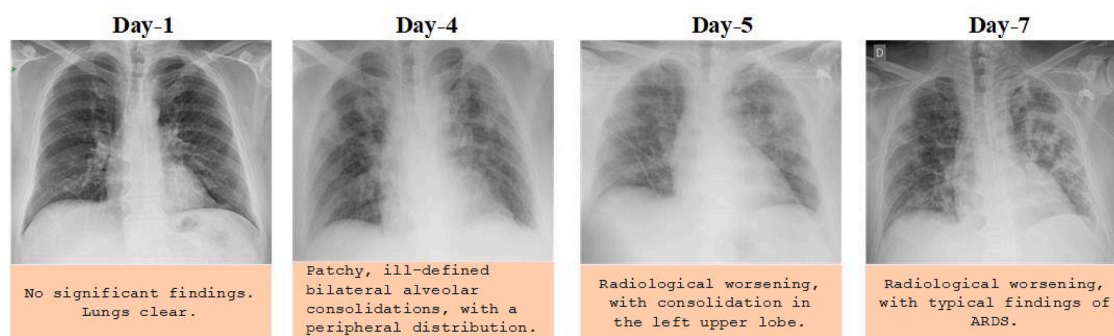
Chest X-ray images of a 50-year-old COVID-19 patient case over a week.
